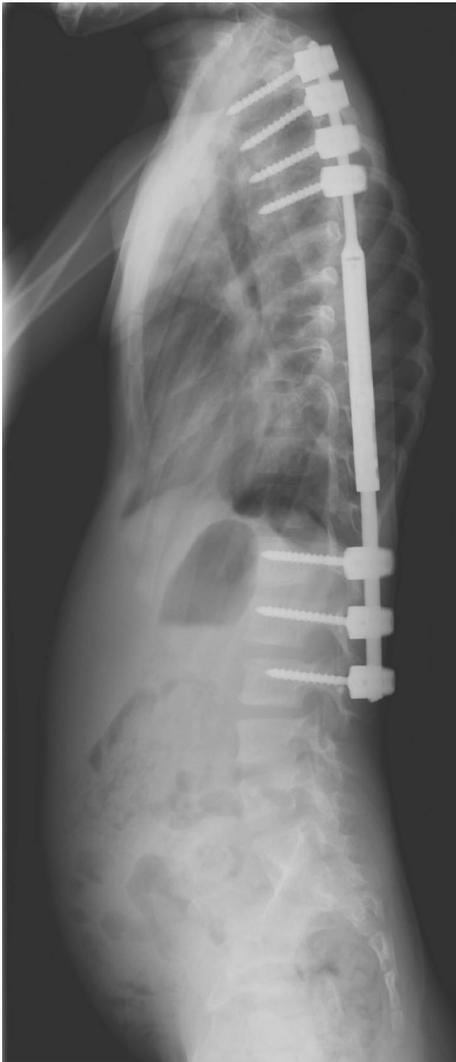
Post-index surgery Cobb angle lateral. First postoperative lateral radiograph of the spine after ratchet rod implantation. Patient no. 10, 3 years old
